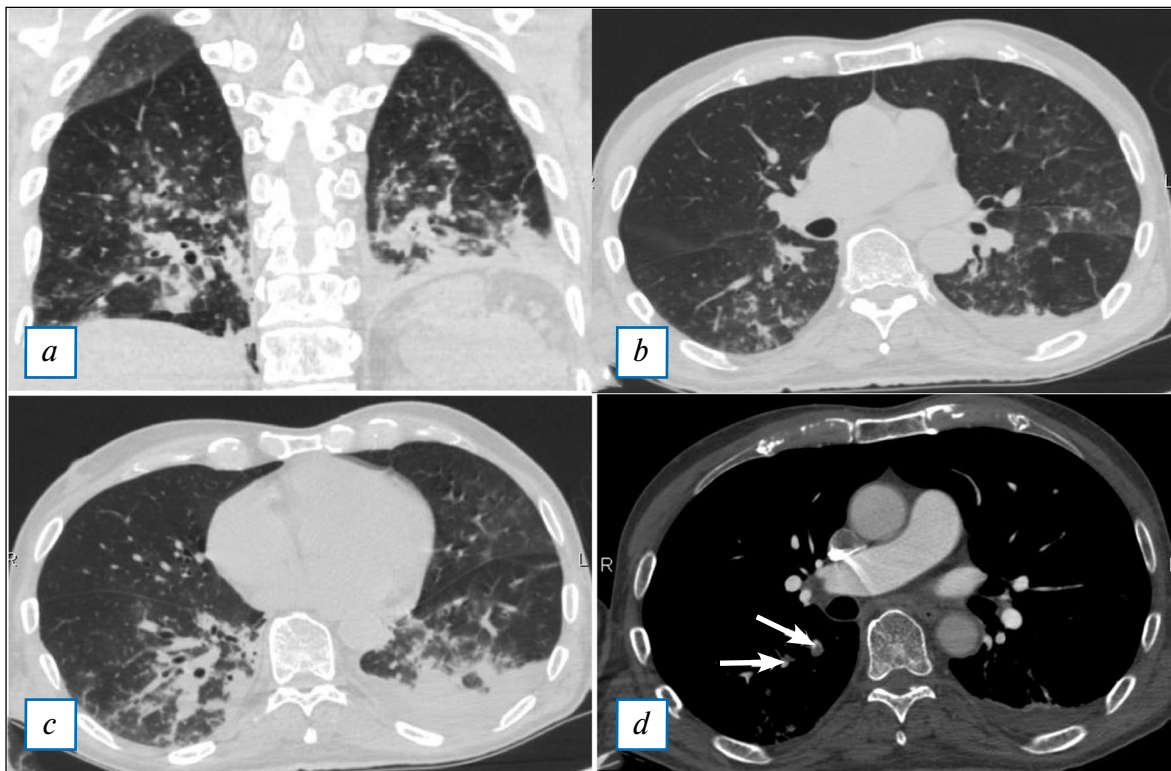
The same patient. CT-scan of the chest: (a-c) — In both lungs (in the upper lobe of the left lung, in S2, S4, segments of the lower lobe of the right lung), areas of «ground glass» and consolidation are determined; (d) — Pulmonary embolism of segmental branches on the right (white arrows).
